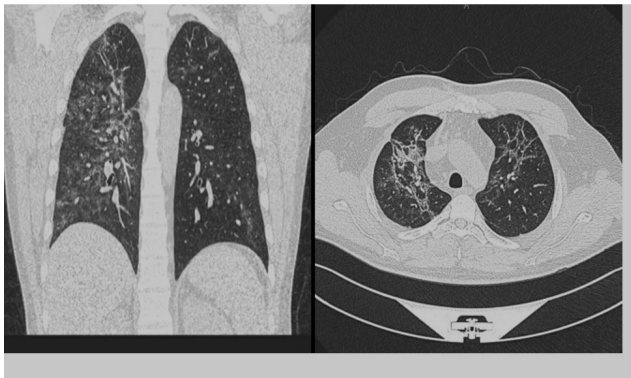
Chest CT-scan showing mainly central ground-glass opacities with septal thickening, areas of consolidation, and fibrotic bands involving the right lung. CT severity: Moderate to severe COVID-19 pneumonia.
